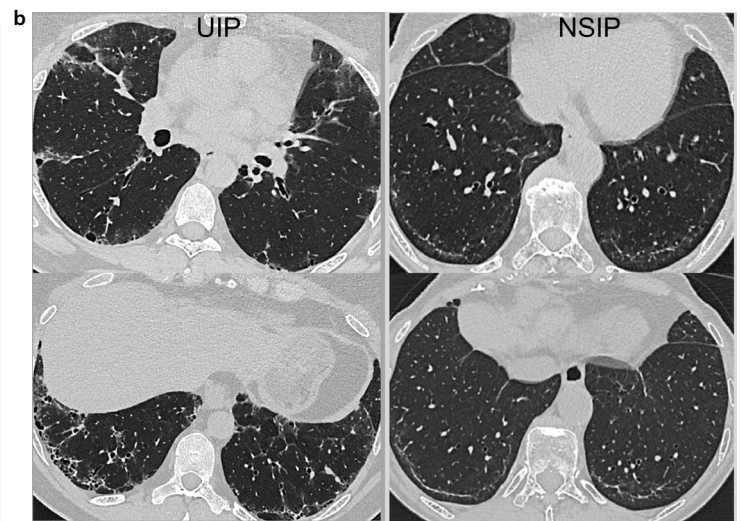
Patterns of ILD identified (a) in the examined RA population (n = 61). Axial 0.2 mm slice thickness chest PCD-CT images representing the most common ILD patterns patients with RA (b) usual interstitial pneumonia (left), non-specific interstitial pneumonia (right). ILD, interstitial lung disease; PCD-CT, photon-counting detector-computed tomography; RA, rheumatoid arthritis; UHR, ultra-high-resolution; HR, high-resolution; dUIP, definitive usual interstitial pneumonia; pUIP, probable usual interstitial pneumonia; iUIP, indeterminate usual interstitial pneumonia; OP, organizing pneumonia; LIP, lymphocytic interstitial pneumonia; DIP, desquamative interstitial pneumonia; PPFE, pleuro-parenchymal fibroelastosis; COVID, coronavirus; NSIP, non-specific interstitial pneumonia; ns, non-significant.
